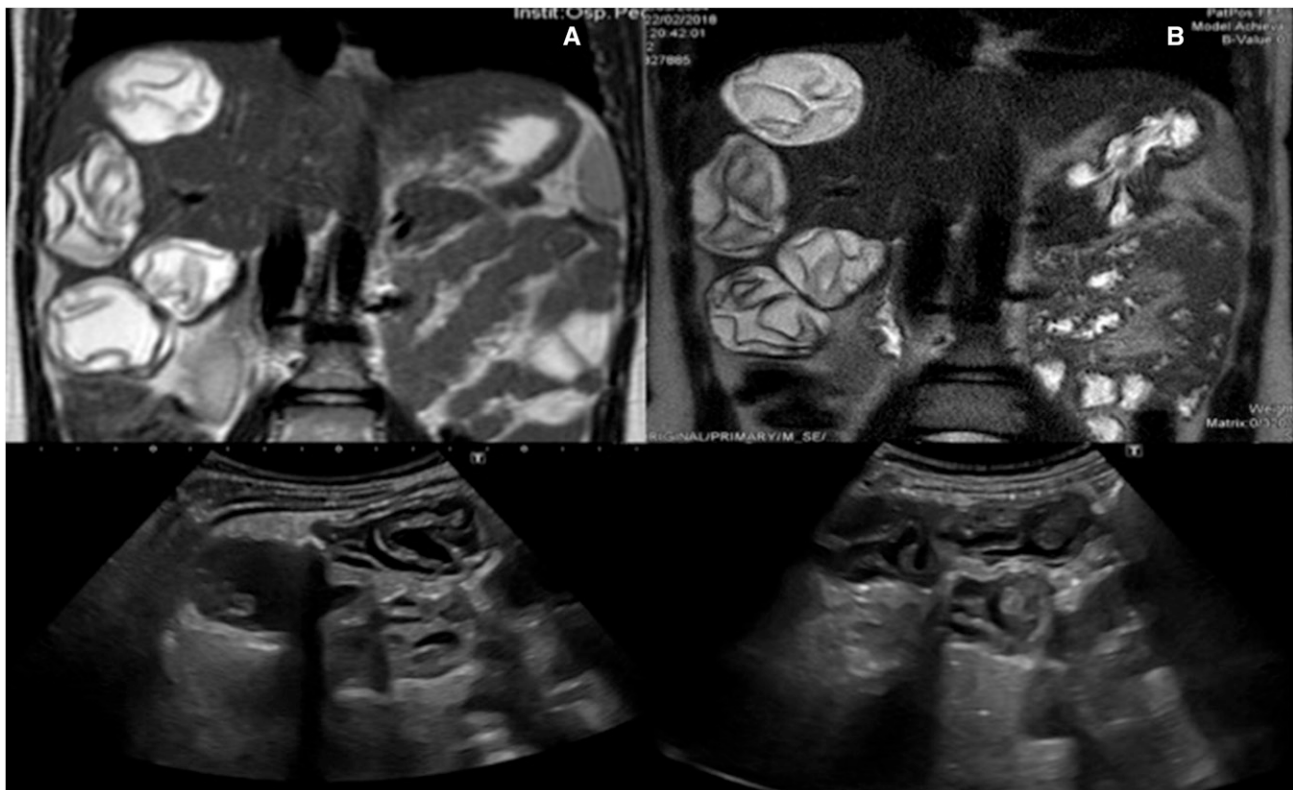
Abdominal magnetic resonance imaging and ultrasound of cysts. (A) Magnetic resonance image performed one month after puncture-aspiration-injection-reaspiration procedure. An involution of all eight hepatic hydatid cysts with modest volumetric reduction was observed. At the completion of echotomography, two cysts had thick flaking membranes, giving a thick semisolid aspect. (B) Magnetic resonance image performed six month after puncture-aspiration-injection-reaspiration procedure. All cysts appeared inactive with a pseudotumor aspect.
